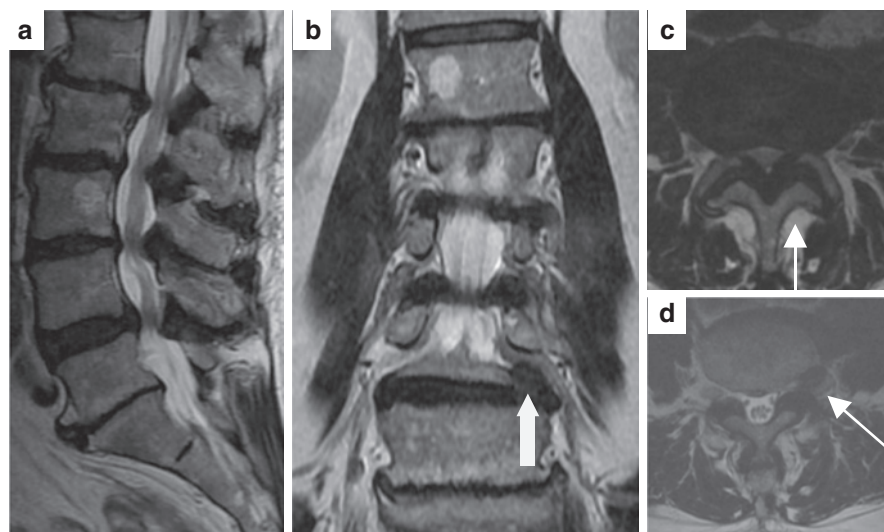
(a) Sagittal T2 MRI lumbar spine demonstrating degenerative changes throughout most notably loss of lumbar lordosis, degenerative disc disease at all visualized levels, and severe stenosis at L3–4 and L4–5. (b) Coronal T2 MRI lumbar spine with foraminal disc herniation on left side at L4–5 (arrow) compressing the exiting L4 nerve root. (c) Axial T2 MRI with severe central stenosis at L3–4. The white arrow indicates the trajectory for the interlaminar approach. (d) Axial T2 MRI with a foraminal disc herniation at L4–5. The white arrow indicates the trajectory for a transforaminal approach
